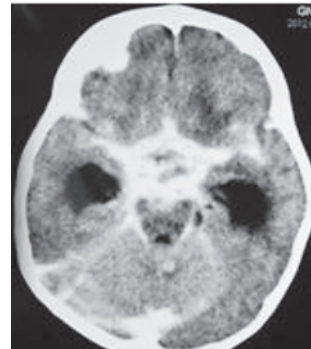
Contrast CT brain showing thick basal exudates and hydrocephalus in TBM
